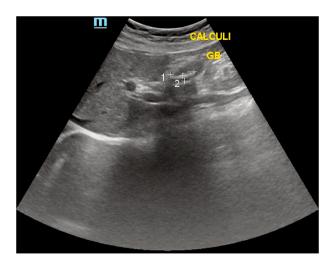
Right upper quadraxnt ultrasound showing multiple calculi.
